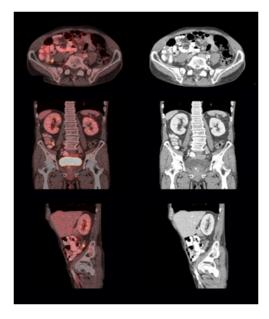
Axial (upper row), coronal (middle row) and sagittal slices of combined PET/CT scan (left) at the level of the appendix. The corresponding CT slices are shown at the right. Marked tracer accumulation is seen in the appendix, which on the sagittal slices is recognized as projecting upwards from the caecum.
